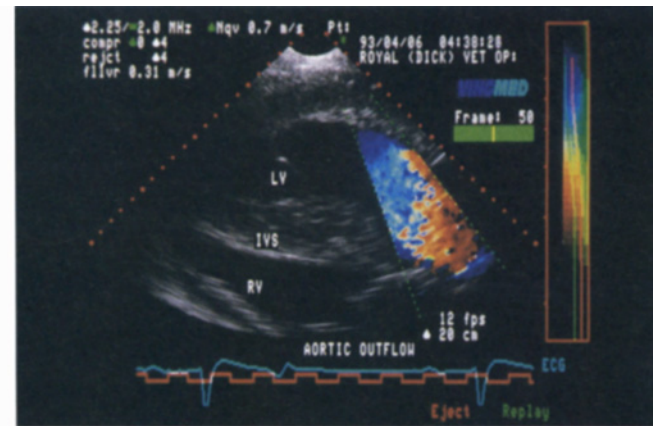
Colour flow Doppler study of the aortic outflow in systole from a left parasternal 5-chambered view. The flow signal is coded blue in the left ventricle but is aliased (coded red) in the left ventricular outflow tract and aorta.
